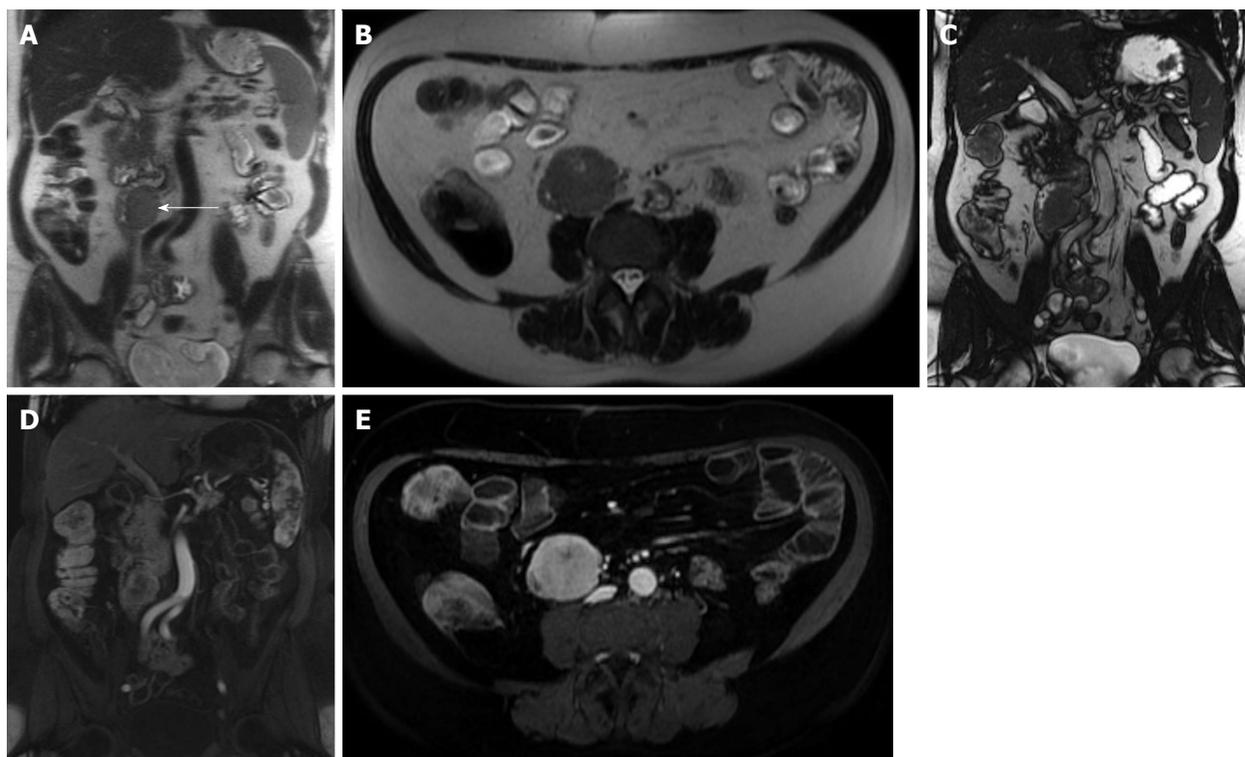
Jejunal gastrointestinal stromal tumor. A: Coronal and (B) axial T2-weighted single shot fast spin echo, and (C) coronal balanced steady state free precession images as well as (D) coronal and (E) axial fat-suppressed post-gadolinium 3D-GRE T1-weighted images. There is a well-defined intramural, exophytic mass lesion arising from the proximal jejunum, in a patient with malrotation, which demonstrates intermediately increased T2 signal (arrow, A, B), early moderate hypervascularity (D) and progressive enhancement (E) post-gadolinium associated with a tiny central area of necrosis in keeping with jejunal gastrointestinal stromal tumor. Lack of proximal bowel obstruction is consistent with its eccentric origin. GRE: Gradient recalled echo.
